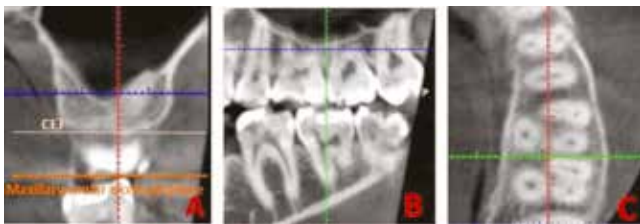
Three views of the CBCT image of interradicular space of left maxillary first and second molars: A, coronal view, with the blue horizontal line at 6.0 mm from buccal CEJ of maxillary first molar; B, sagittal view, with the green vertical reference line bisecting interradicular space; C, axial view, with the green horizontal reference line bisecting mesiodistal interradicular space between maxillary first and second molars.
